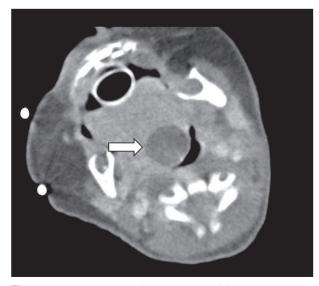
A contrast computed tomograph (axial section) shows a hypodense circular cyst (arrow) in the foramen cecum.
